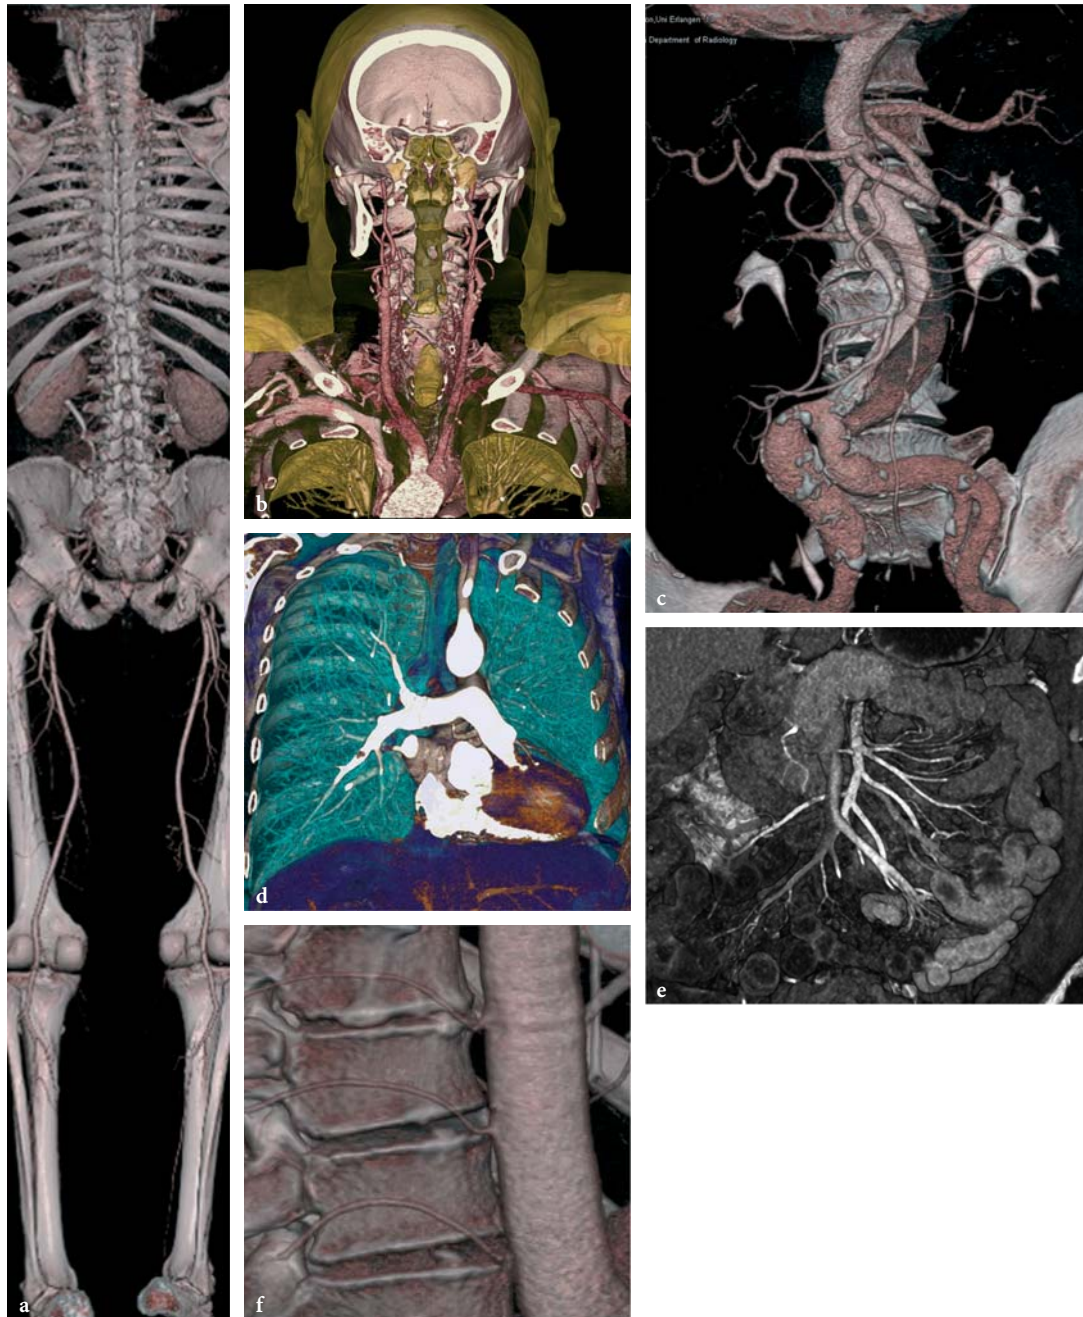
Case examples of 64-slice CT angiography examinations using a CT scanner with 0.6-mm collimation and double z-sampling technique. Whole-body CT angiography examination with 0.4-mm resolution and 1570-mm scan range (a). Pure arterial-phase carotid artery examination in 5-s scan time (b). CT angiography of a dissection of the abdominal aorta with excellent visualization of calcifications and small-caliber abdominal vessels (c). Detection of pulmonary embolism in a patient with chest pain within a breath-hold time of 5 s (d). CT angiography of the mesenteric arteries in a patient with acute bowel ischemia (e). Display of small vessels with calibers of < 1 mm originating from the thoracic aorta perpendicular to the scan axis (f). (Cases courtesy of the University of Erlangen, Germany)
